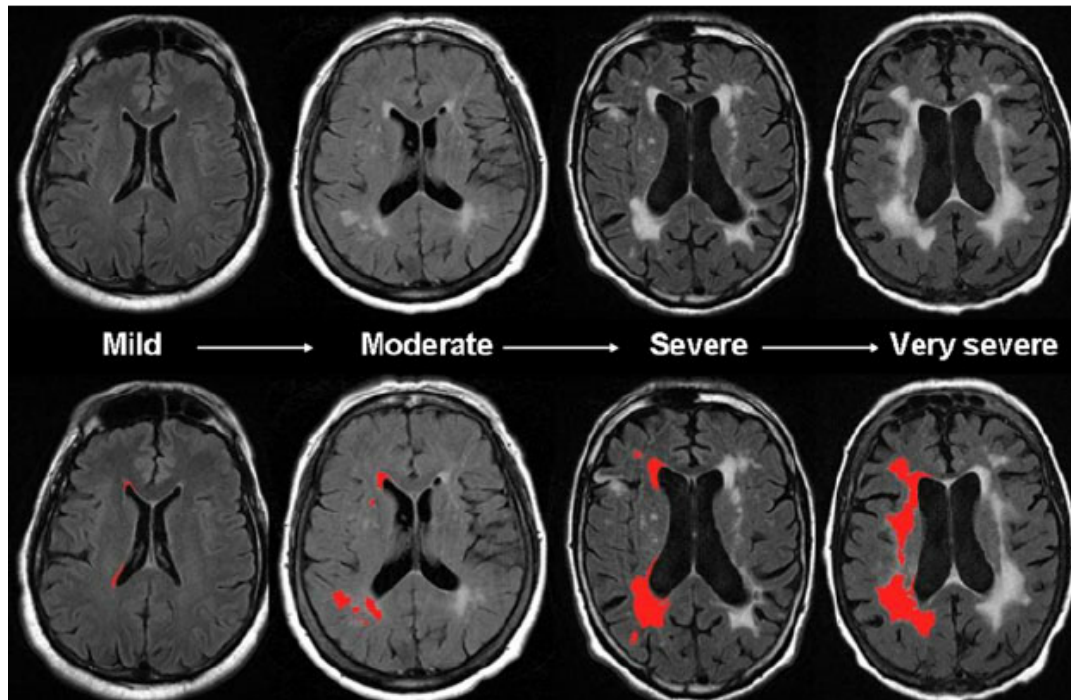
Severity of MRI-detected white matter hyperintensities (WMH), where red indicates regions of WMH. Total burden of white matter disease varies significantly amongst symptomatic and asymptomatic CADASIL patients. Image and caption retrieved from Chutinet and Rost (2014).
